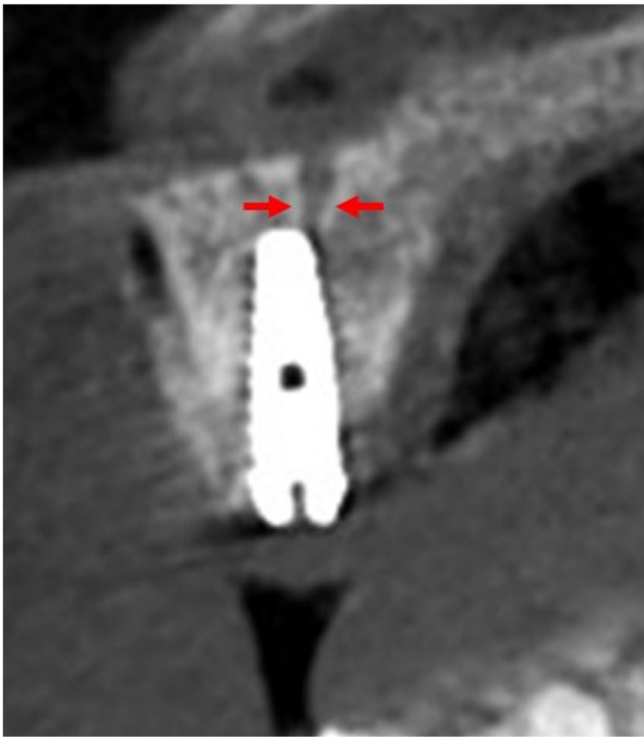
Paraxial CBCT image showing the implant in position #11 compressing the Canalis Sinuosus (CS)
